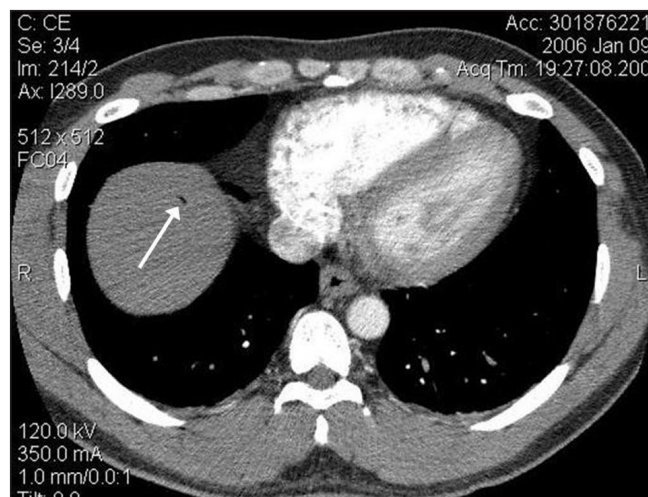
Computed tomography scan of the abdomen showing the presence of portal venous gas (arrow)
